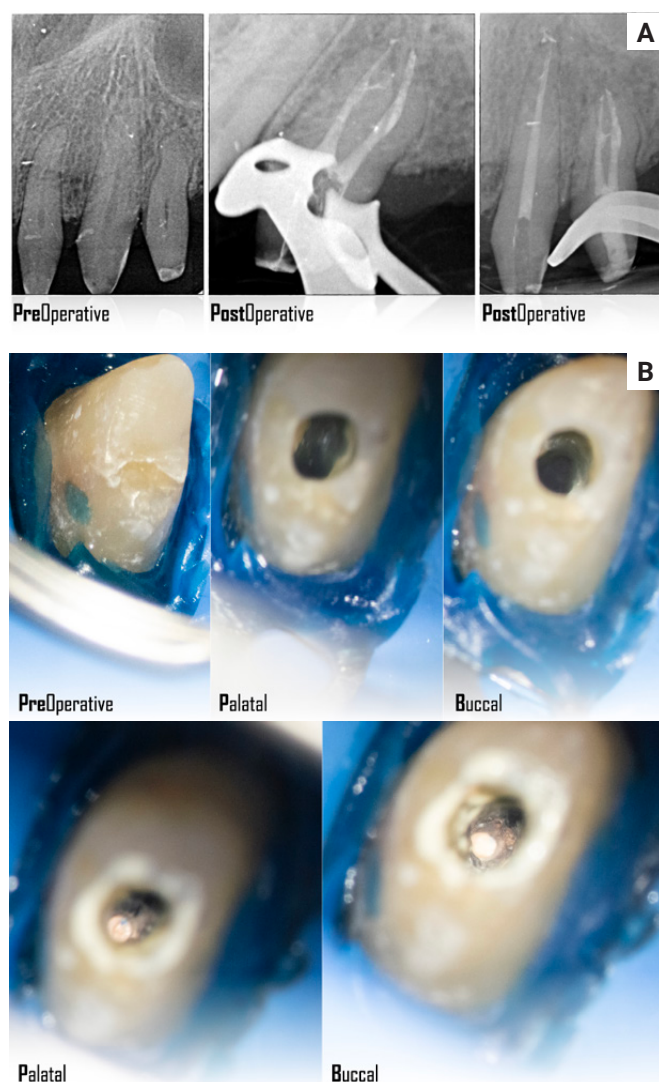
3D obturation on premolar (Continuous wave of condensation, elements™ IC, gutta-percha and Sealapex™ Kerr) - A) X-rays before and after obturation of root canals; B) clinical images – before, during and after root canal obturation.
